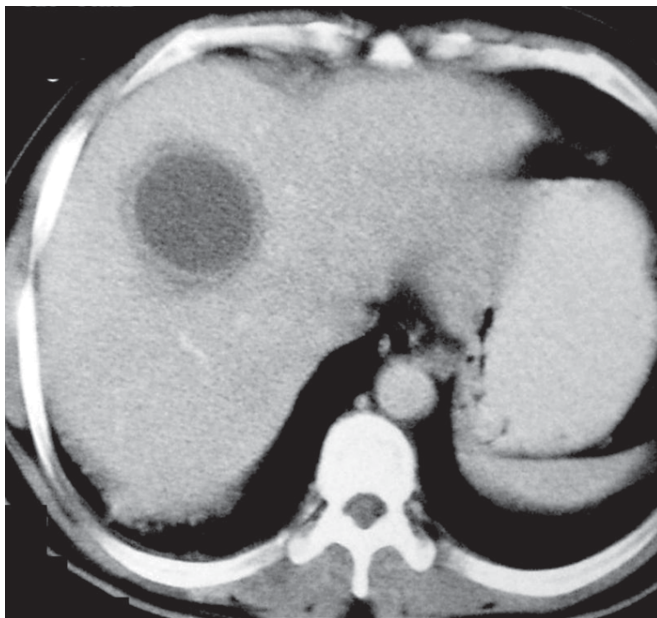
Axial contrast-enhanced CT reveals the presence of a unilocular low-attenuation mass with a peripheral enhancing rim in the right lobe of the liver, suggestive of a liver abscess. The characteristic ‘double target sign’ due to the presence of a low attenuation peripheral rim as a result of perilesional oedema is also seen.
